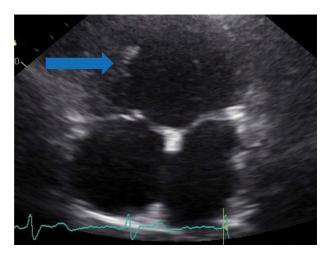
Echocardiogram showing single ventricle (arrow) with double inlet etiology.
